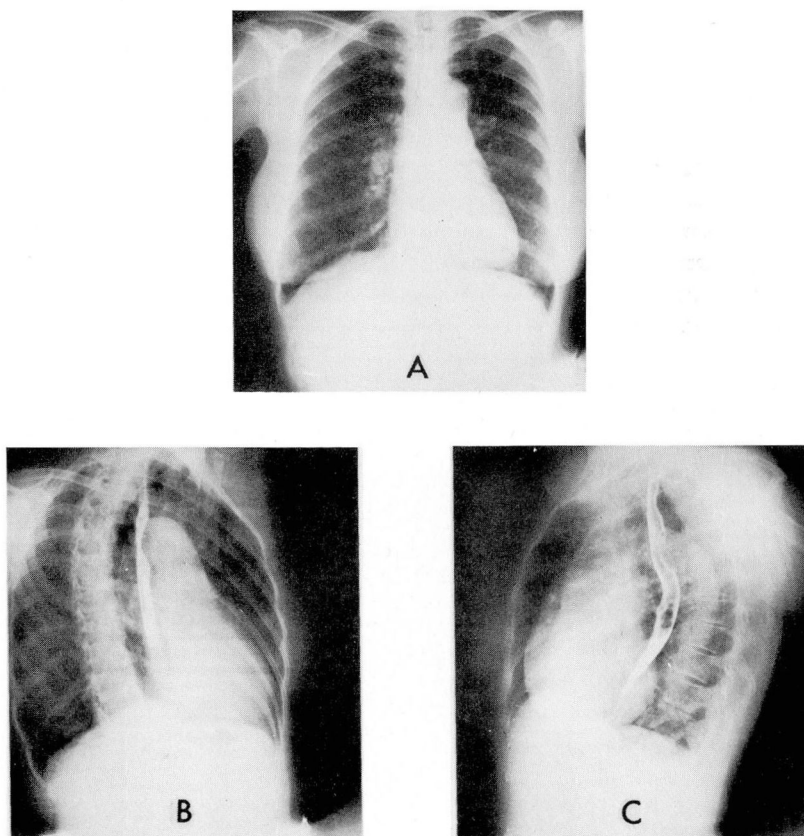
Progress roentgenograms of the chest 15 months postoperatively. The transverse cardiac diameter was 12 cm.
